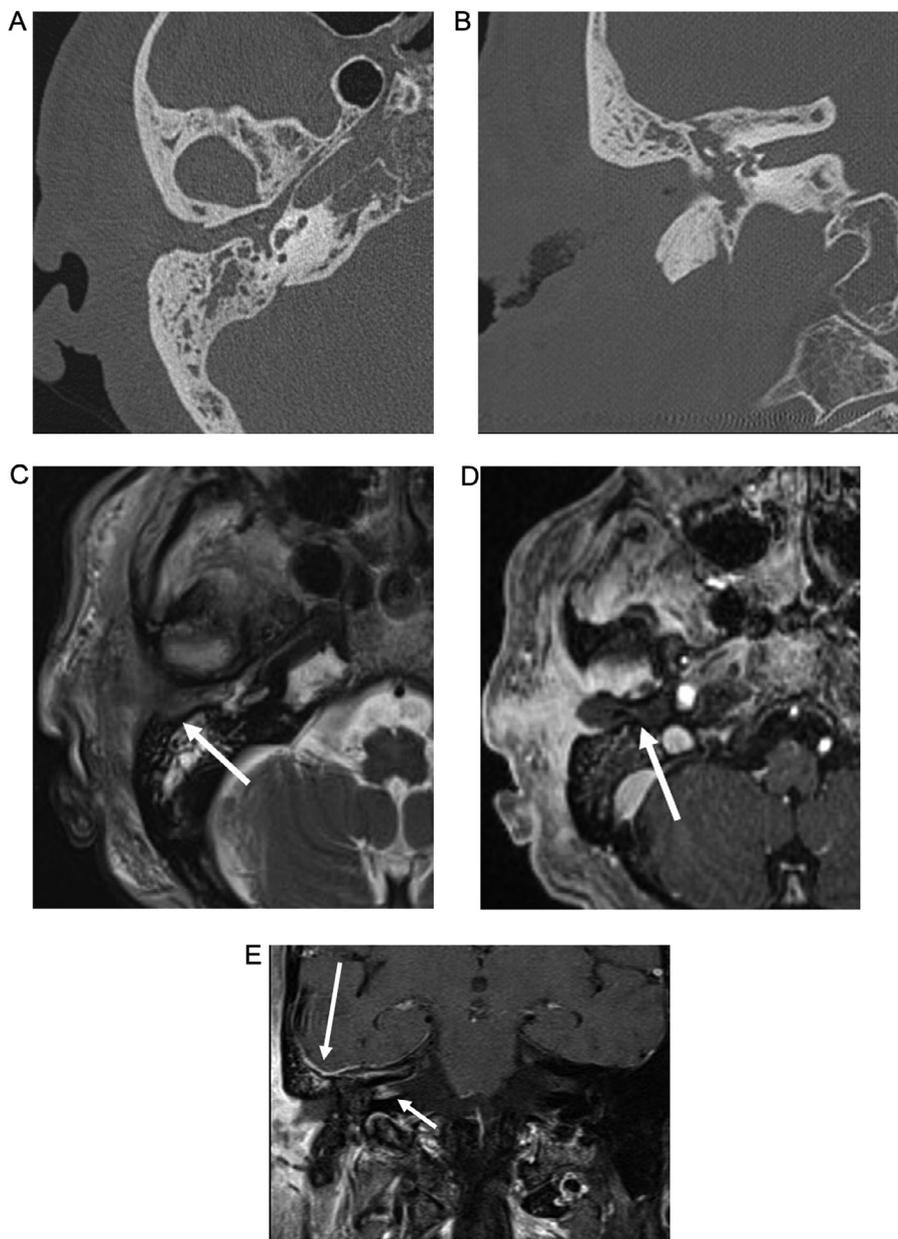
65 m h/o AML and acute onset facial weakness with fungal infection. Axial (A) and coronal (B) CT images show soft tissue within the EAC without osseous erosion. Axial T2W image (C) shows hypointense soft tissue within the EAC (arrow) and extending into the surrounding soft tissues with adjacent areas of hyperintense edema. Axial post-contrast T1W image with fat saturation (D) shows enhancement and extension of the infection anteriorly into the TMJ and masticator space. Much of the soft tissue in the EAC shows lack of enhancement consistent with debris and necrotic mucosa (arrow). Coronal postcontrast T1W image with fat saturation (E) shows enhancement of cranial nerves and dura within the internal auditory canal (short arrow) and mild dural thickening in the middle cranial fossa (long arrow).
